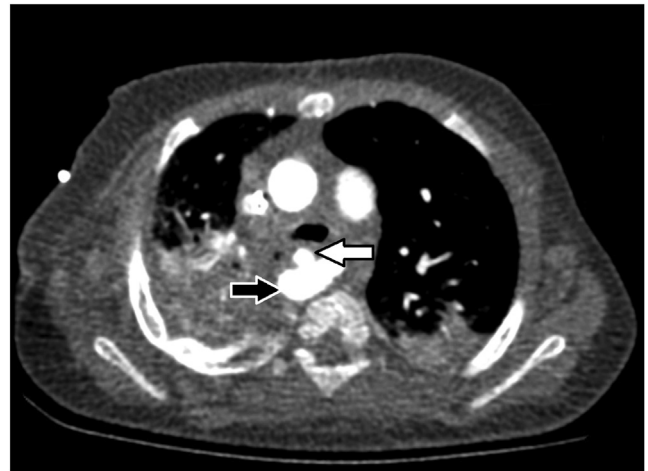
Image from patient 4 Axial slice from CTA of patient 2 showing apex of aortic arch (black arrow with white border) and pseudoaneurysm (white arrow with black border).
